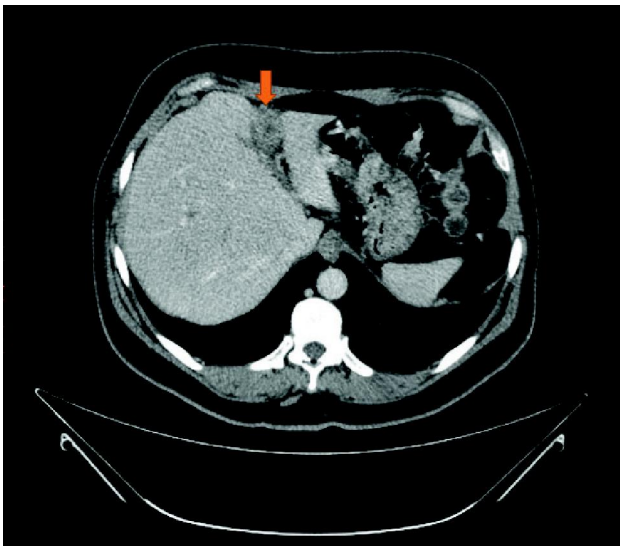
Contrast enhanced CT scan (portovenous phase, axial view) showing ill-defined hypodense mass in the region of falciform ligament with associated significant perifocal inflammatory reaction (red arrow).
